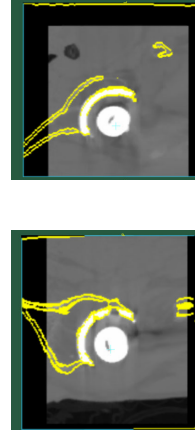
Pelvic bone and cup edge maps derived from tracking these structures from the baseline timepoint, displayed over the follow-up CT scan in the sagittal plane (left image) and coronal plane (right image).
